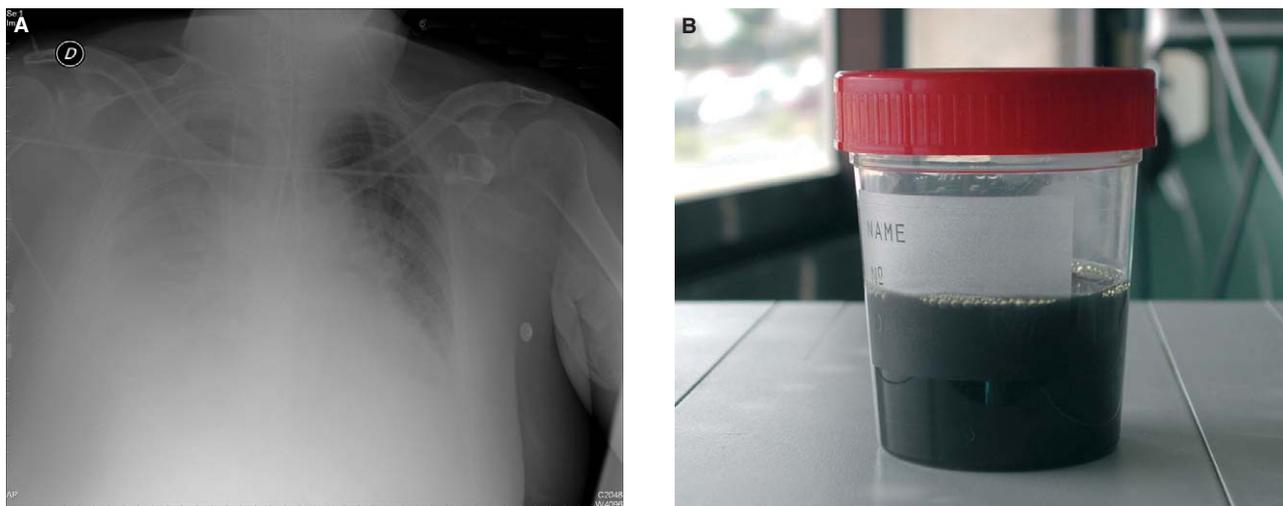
chest radiography at admission to our unit shows diffuse opacification in the right thorax, indicative of right pleural effusion. B: macroscopic characteristics of the fluid taken from the pleural cavity.
